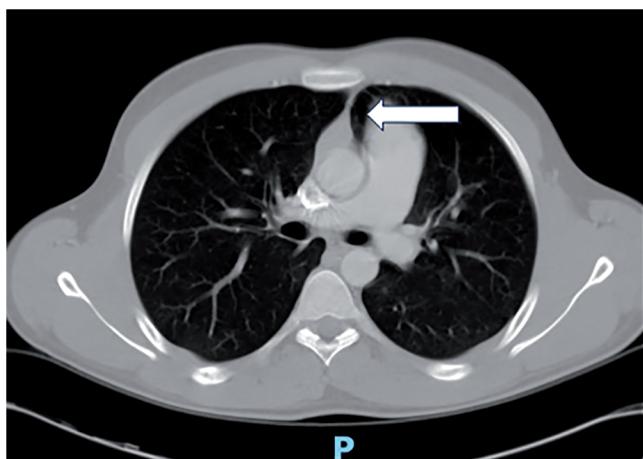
Computed tomography scan showing a tongue of lung tissue between the aorta and main pulmonary artery (white arrow). This is typical of CAP. The aortopulmonary window is usually bounded by pericardium and contains fat (previously unpublished image belonging to the authors)
